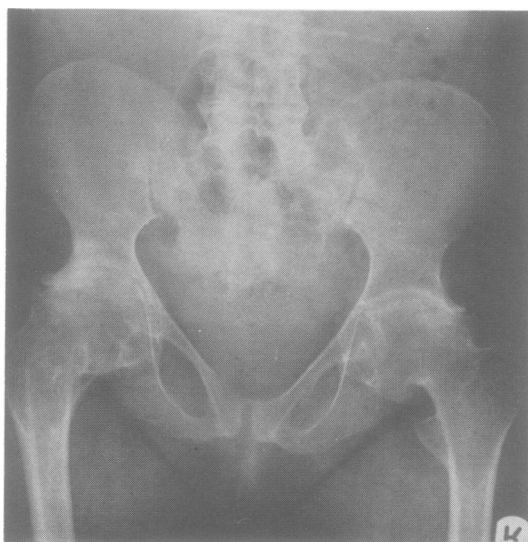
Radiograph of the pelvis.
